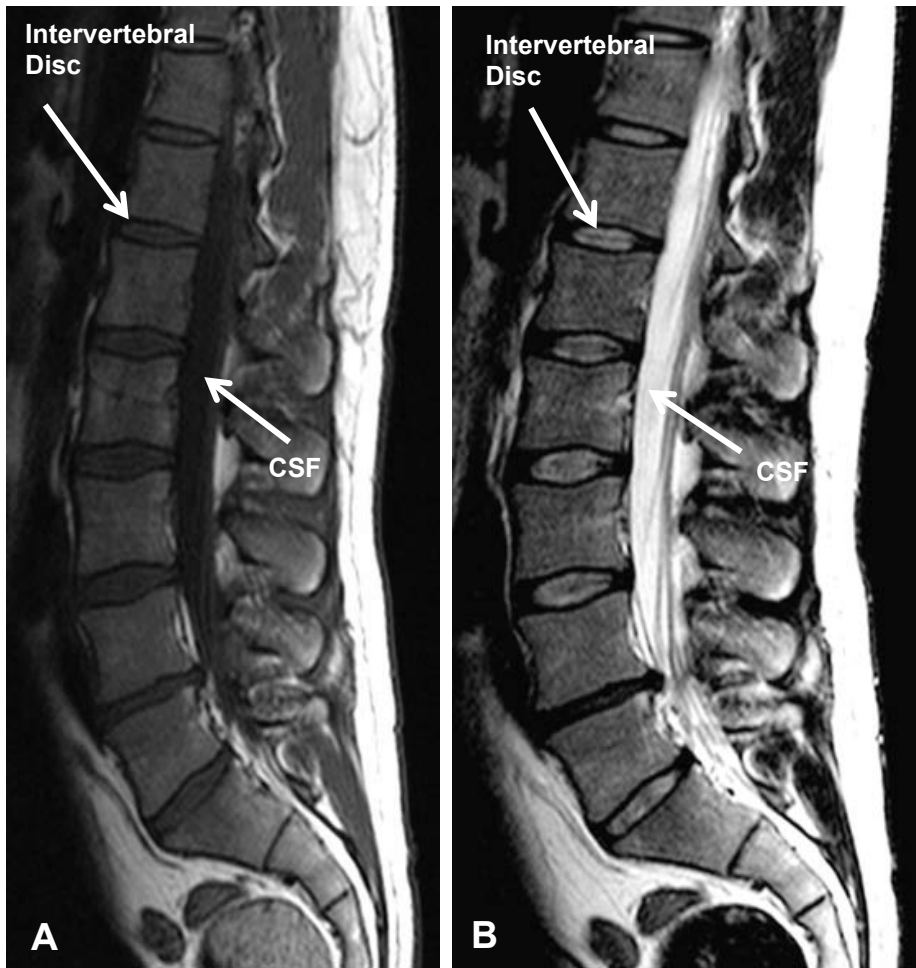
Sagittal images of the spine. (A) T1-weighted. (B) T2-weighted. Note the relative brightness of CSF and intervertebral discs on image B. *Courtesy of University of Iowa Carver College of Medicine.*
